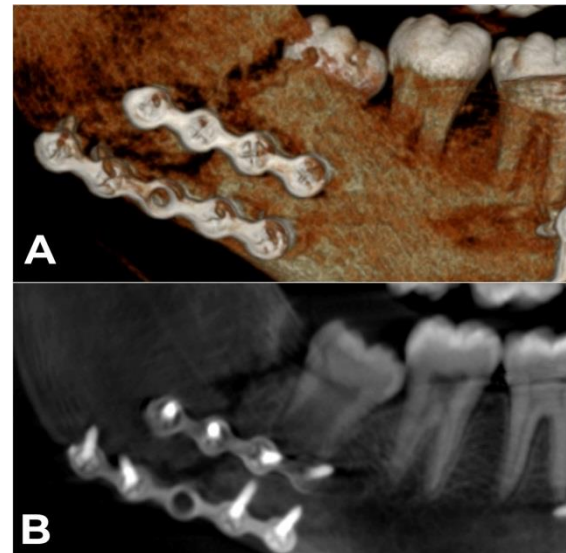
Postoperative CBCT scan for Standard miniplates: (A: 3D view - B: Panoramic view)
